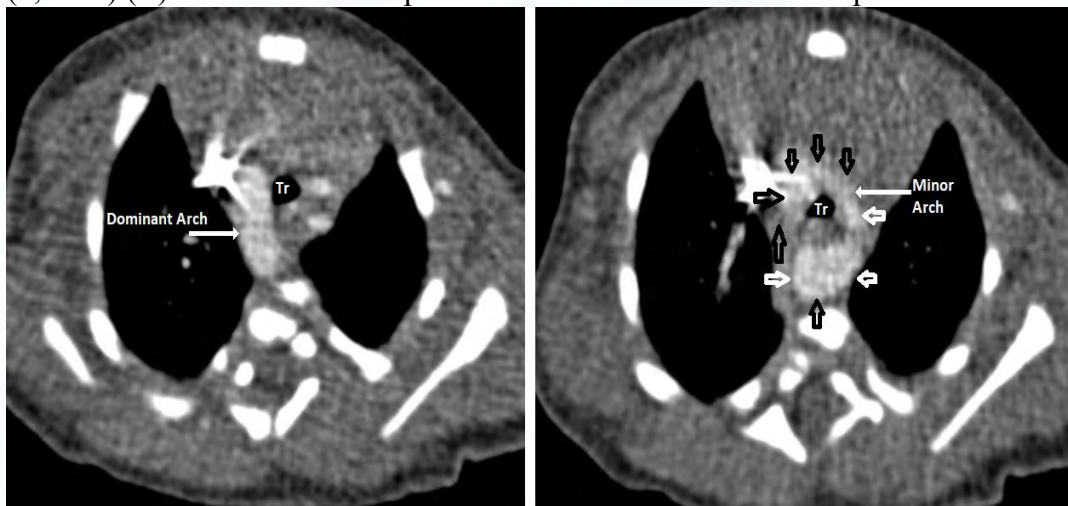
Postnatal thoracic CT angiographic examination revealed that the dominant arch located in the right posterior enveloped the trachea (Tr) via the left and anterior arches, and the two arches joined together to form the descending aorta.
